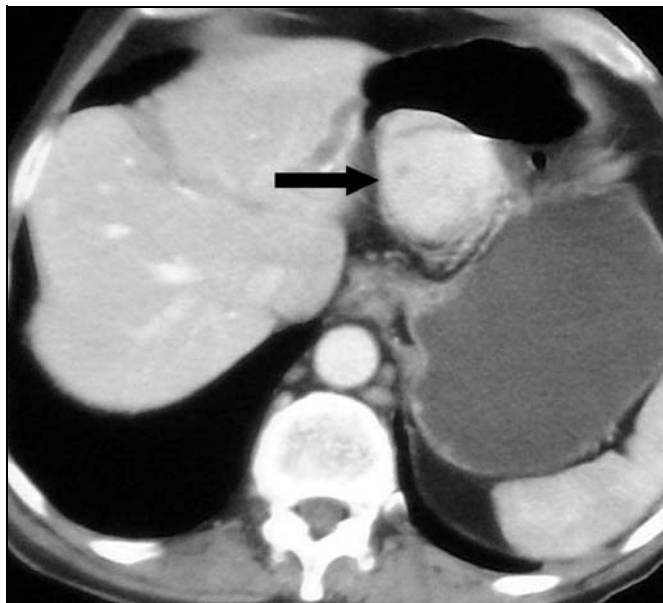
30-year-old man with gastric gastrointestinal stromal tumor. Axial contrast-enhanced CT scan of upper abdomen shows intense homogenous enhancement of tumor arising from gastric wall (arrow).
